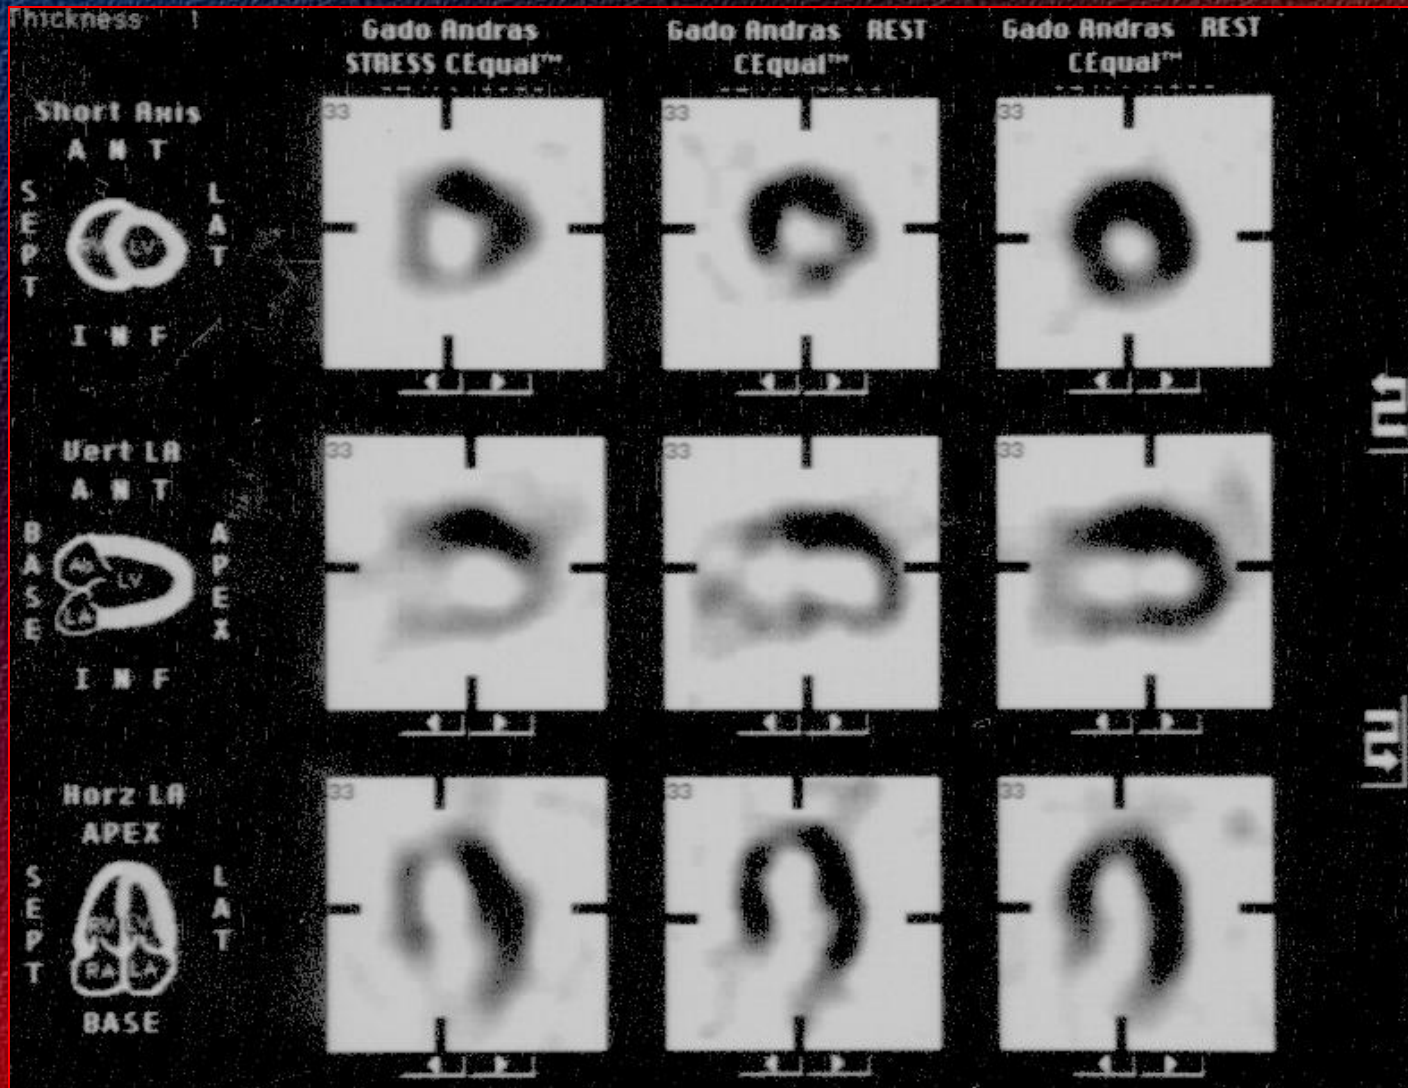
displays a series of 36 short-axis SPECT myocardial perfusion images arranged in a 6x6 grid. The grid is organized into three rows of stress images and three rows of rest images. The columns represent different slices, numbered 30 to 36. The top row of stress images shows normal perfusion. The middle row of stress images shows a large perfusion defect in the anterior wall. The bottom row of stress images shows a large perfusion defect in the inferior wall. The rest images show normal perfusion. The grid is labeled with 'STRESS CEqual', 'REST CEqual', 'ANT', 'INF', 'BASE', 'APEX', 'SEPT', 'LAT', 'Short Axis', 'Vert Long Axis', and 'Horiz Long Axis'.
